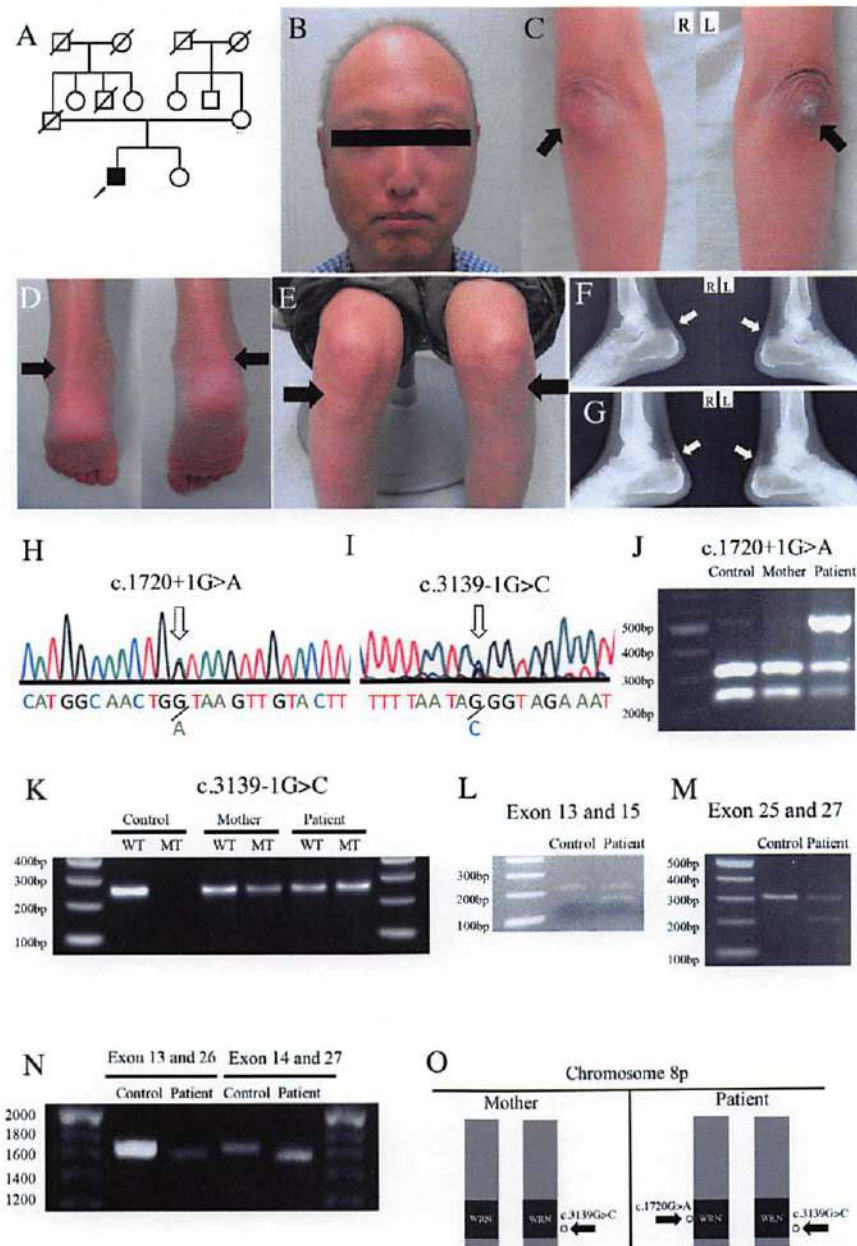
The patient's (A) family tree, (B) characteristic "bird-like face" and senile appearance, (C, arrows) cutaneous hyperkeratosis in bilateral elbows, (D, arrows) knees and (E, arrows) ankles. (F and G, arrows) X-ray showing the segmented calcification of the Achilles tendons at the diagnosis and five years later. The patient's (H and I, arrows) direct DNA sequence of the WRN gene revealed a c.1720+1G>A substitution in intron 14 and c.3139-1G>C substitution in intron 25 (2), which was (J) confirmed by PCR-RFLP and (K) AS-PCR for the patient and his mother. RT-PCR spanning (L) exons 13 to 15, (M) exons 25 to 27, (N) exons 13 to 26 and exons 14 to 27, confirming that (O) skips in exons 14 and 26 take place in different alleles.
